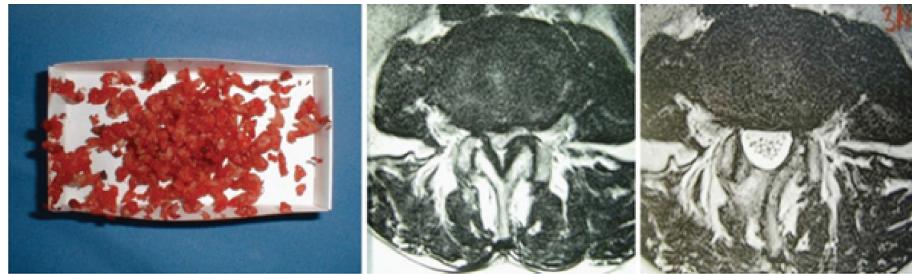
From [8] with permission. “Technical result” of decompression of one level (L3-4). Left: material that has been removed (yellow ligament, bone). Middle: MRI preoperatively; right: MRI postoperatively shows a complete decompression with preserved facet joint and minimum scar tissue formation in the muscles.
